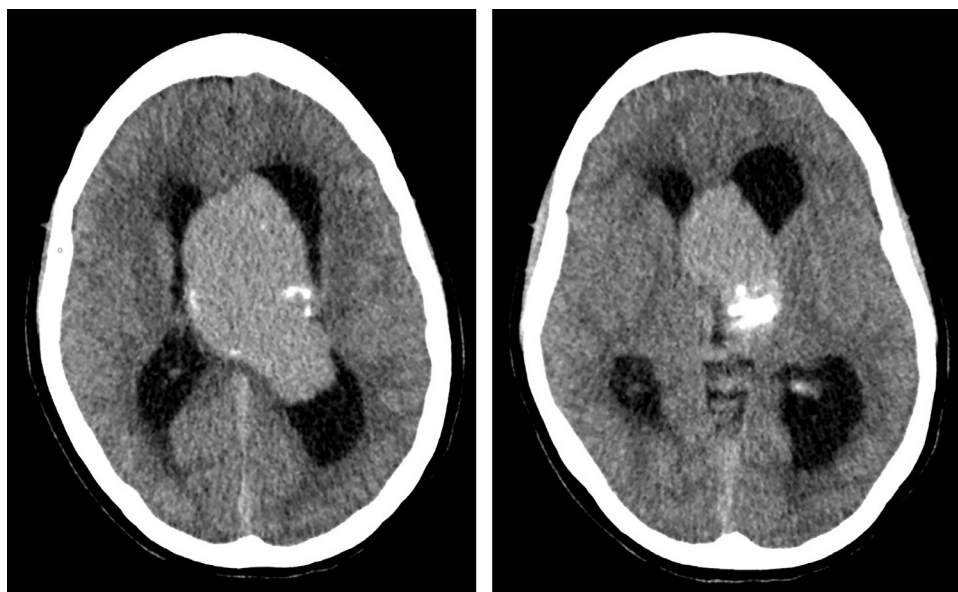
Brain CT : intraventricular mass with calcifications occupying the body of the left ventricle with broad contact with the septum pellucidum and the foramen of Monro. Lateral ventricular dilatation is present with transependymal edema and effacement of the sulci.
